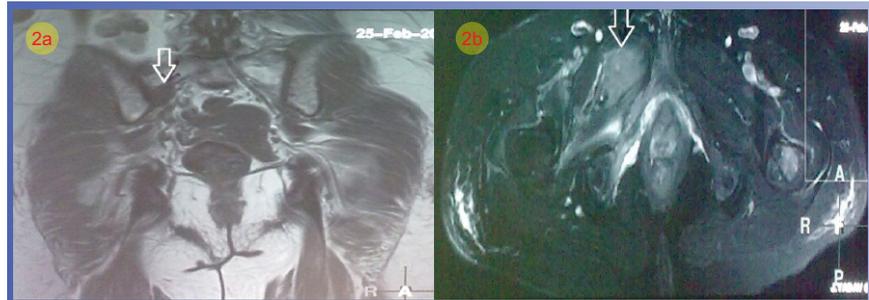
Coronal and axial T1 MRI images of the pelvis shows the expansile osteolytic lesion of the right pubis with associated lobulated soft tissue involvement (arrow shown).
